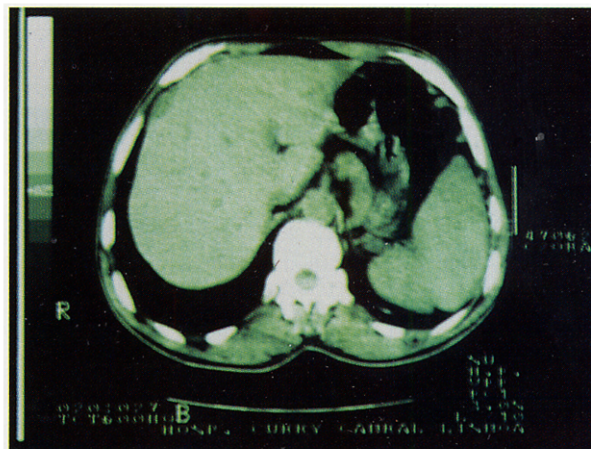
Abdominal CT scan shows hypodense liver lesion suggestive of bacillary peliosis (arrow).
